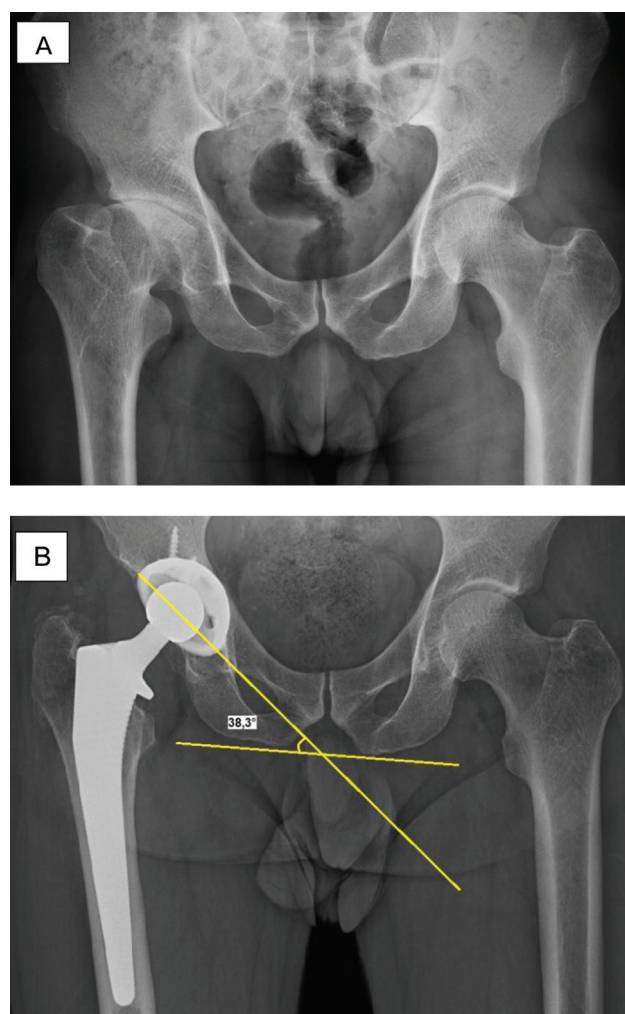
Acetabular component inclination in relation to the pelvis. Demonstration of the lines used to calculate the angle in anteroposterior hip radiographs. (A) Preoperative view. (B) Final follow-up and angle calculation.
